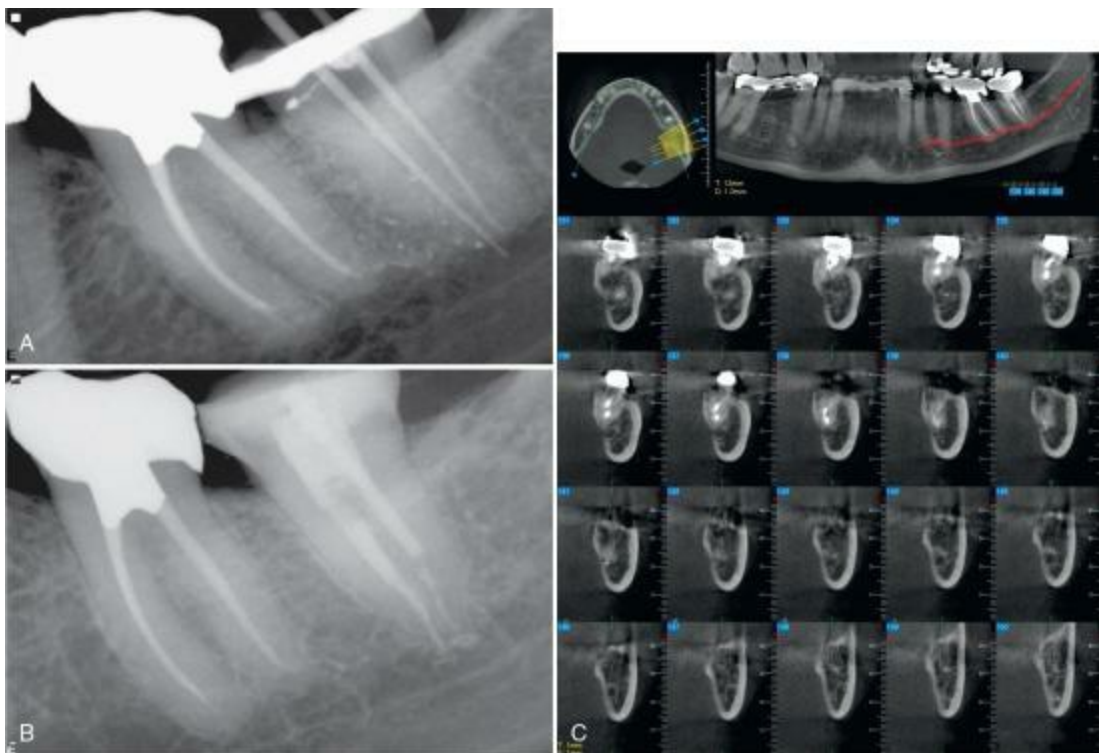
A, Unclear periapical radiograph shows both cortical borders of inferior alveolar nerve canal (IANC). B, Cones placed into IANC, showing measurements beyond apices. C, Overfill into IANC better shown on cone-beam computed tomography (CBCT) than periapicals of A and B.
